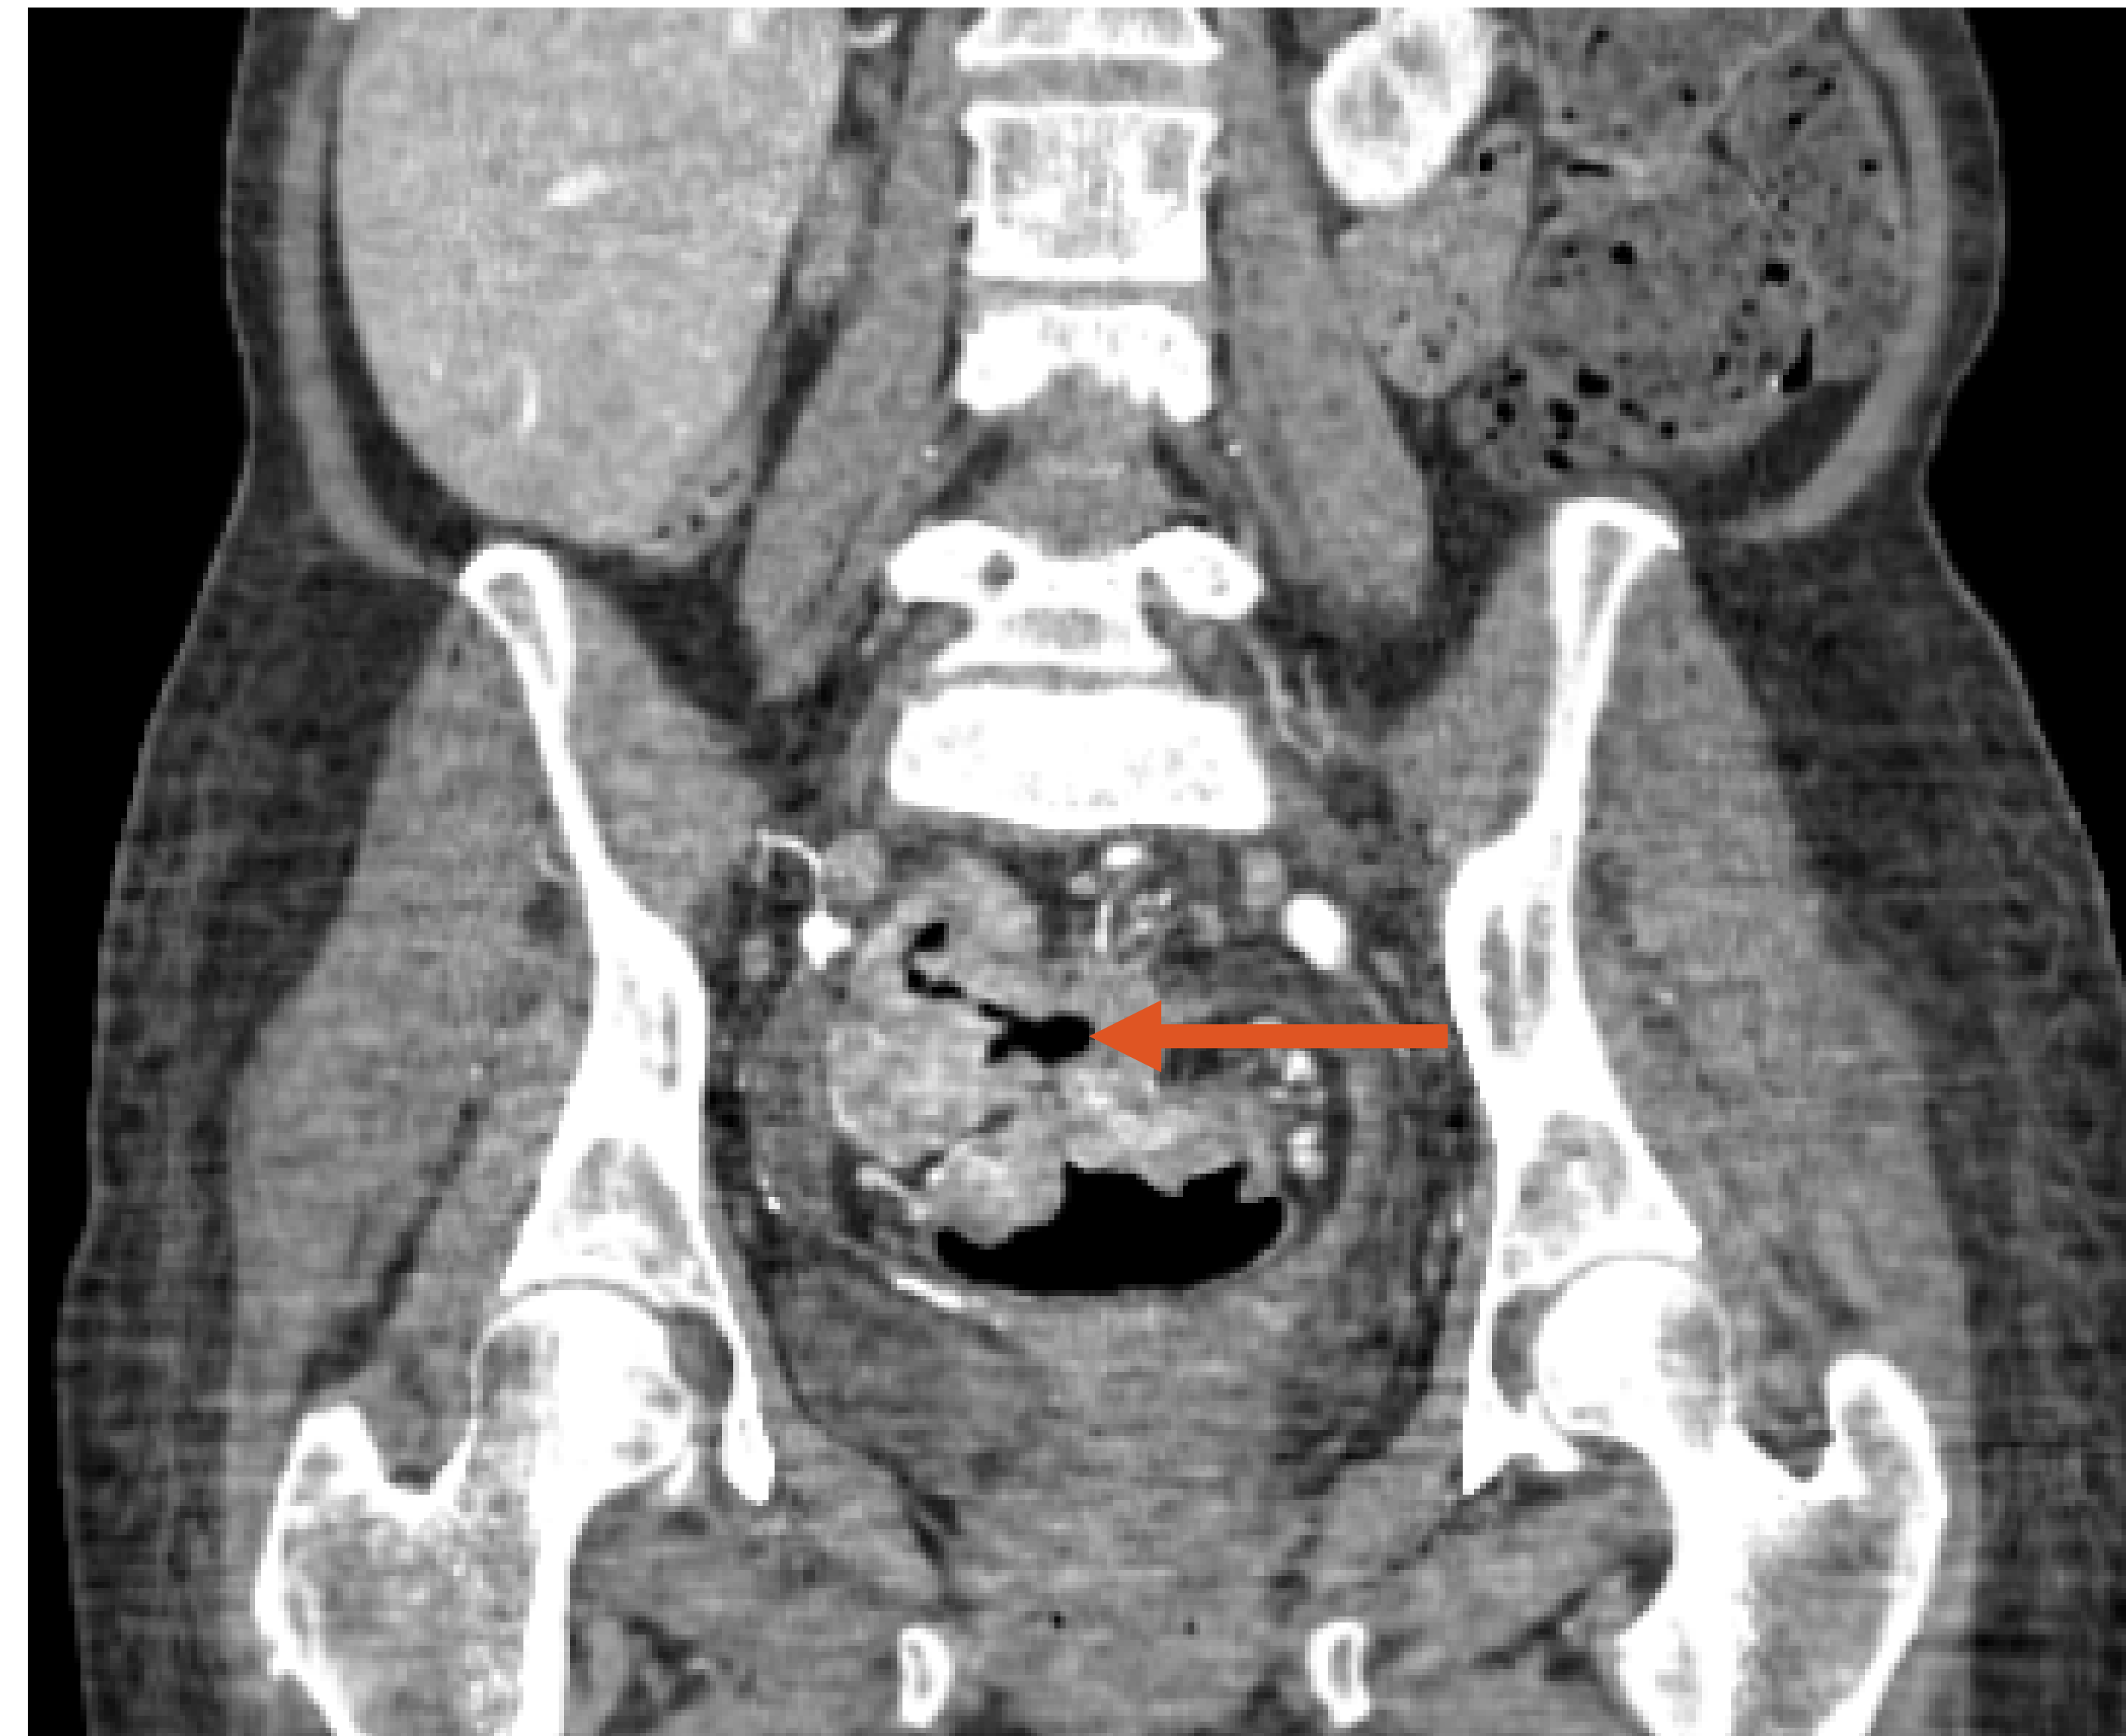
Coronal View CT Abdomen/Pelvis Without Contrast showing Inflammation and Contiguous Spread of Colonic Adenocarcinoma to the Adjacent Small Bowel (Orange Arrow).
